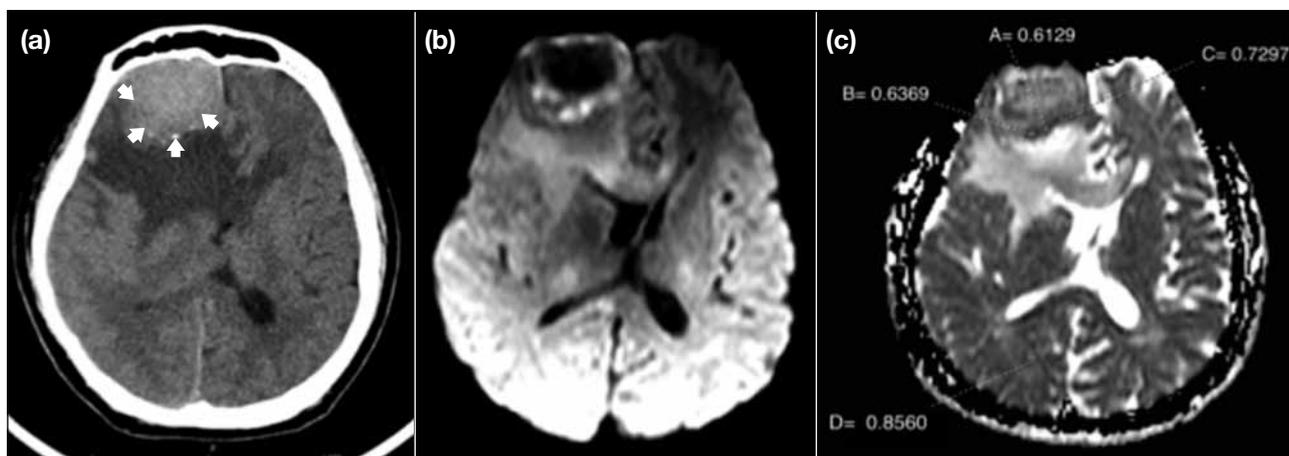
Patient No. 6: atypical meningioma (grade II) at right frontal pole in a 69-year-old man with (a) large area of central calcification confirmed by plain axial computed tomographic scan (arrows). (b) Diffusion-weighted imaging reveals large area of central hypointense signal surrounded by peripheral mixed signal intensity. (c) The mean apparent diffusion coefficient (ADC) value measured from three regions of interest (A, B, and C) in the peripheral area without calcification was $0.6680 \times 10^{-3} \text{ mm}^2/\text{s}$. The normalised ADC value with reference to the normal white matter (D) was 0.7804.
